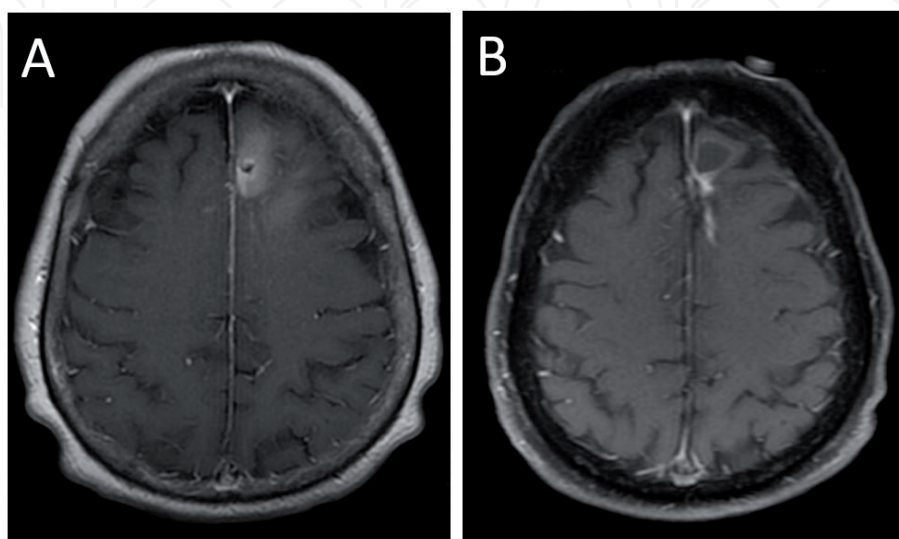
(A) A 69-year-old female patient with progressive enhancement after treatment of metastatic lung adenocarcinoma. (B) Post-LITT procedure T1-weighted MRI with contrast shows successful lesion ablation.
